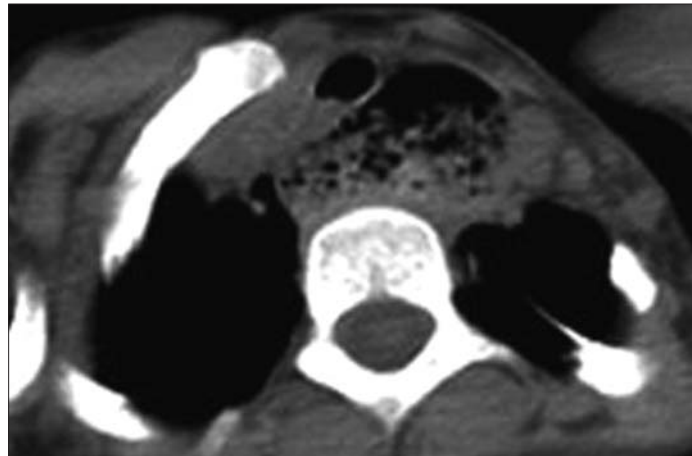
Axial chest CT image shows the pouch of the diverticulum filled with air and food particles, compressing the trachea.
